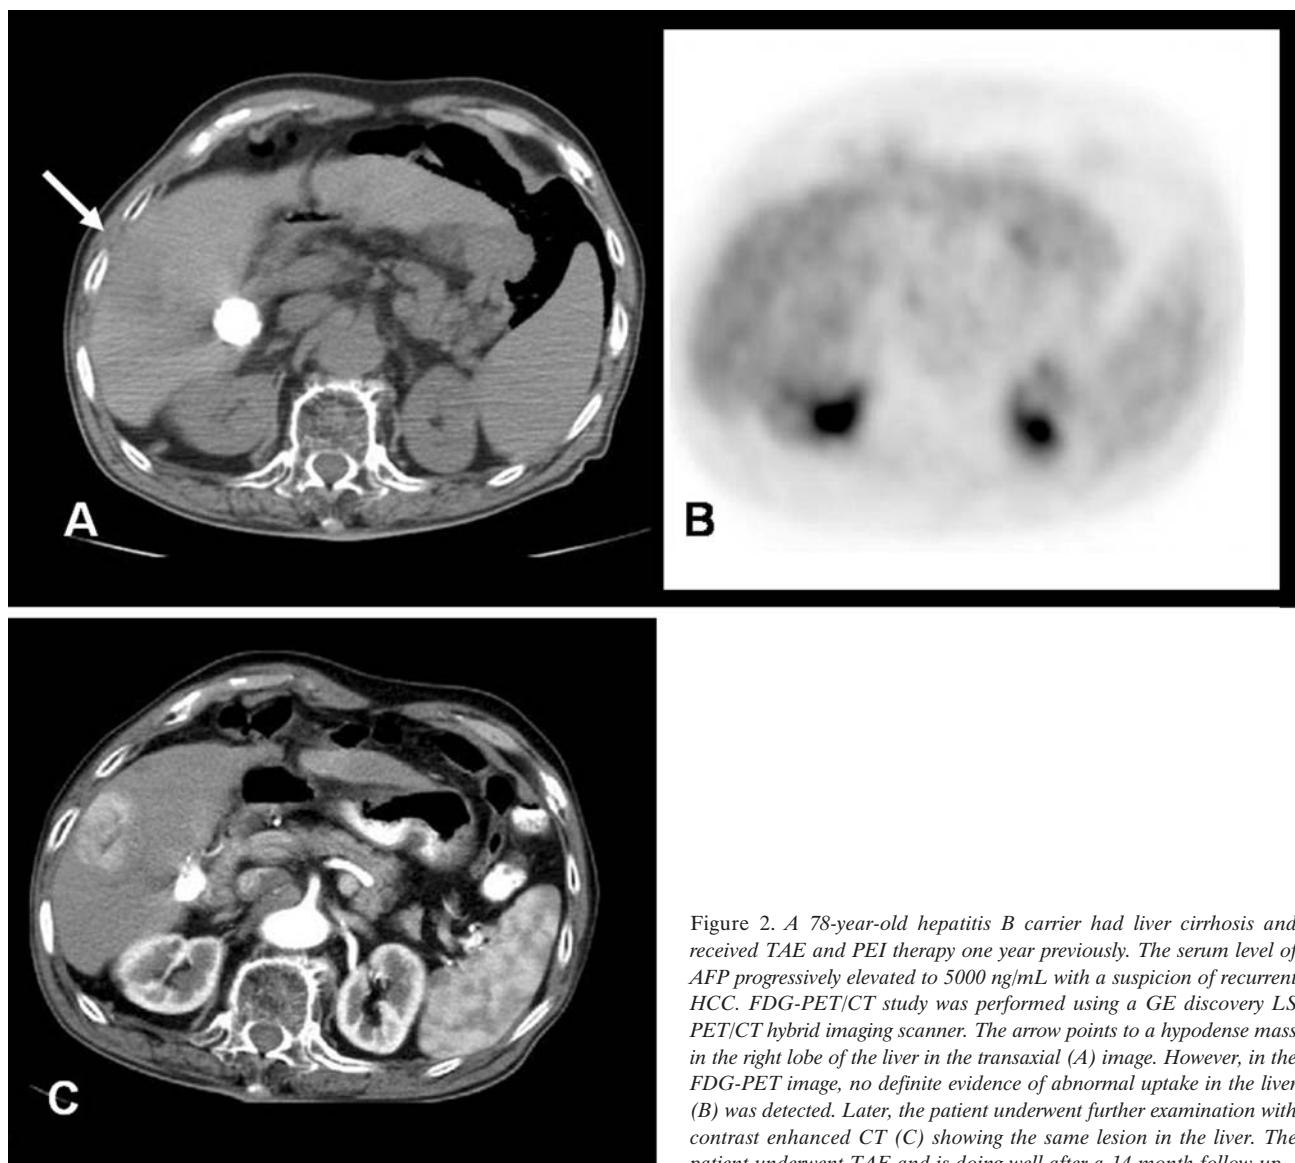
A 78-year-old hepatitis B carrier had liver cirrhosis and received TAE and PEI therapy one year previously. The serum level of AFP progressively elevated to 5000 ng/mL with a suspicion of recurrent HCC. FDG-PET/CT study was performed using a GE discovery LS PET/CT hybrid imaging scanner. The arrow points to a hypodense mass in the right lobe of the liver in the transaxial (A) image. However, in the FDG-PET image, no definite evidence of abnormal uptake in the liver (B) was detected. Later, the patient underwent further examination with contrast enhanced CT (C) showing the same lesion in the liver. The patient underwent TAE and is doing well after a 14-month follow-up.
